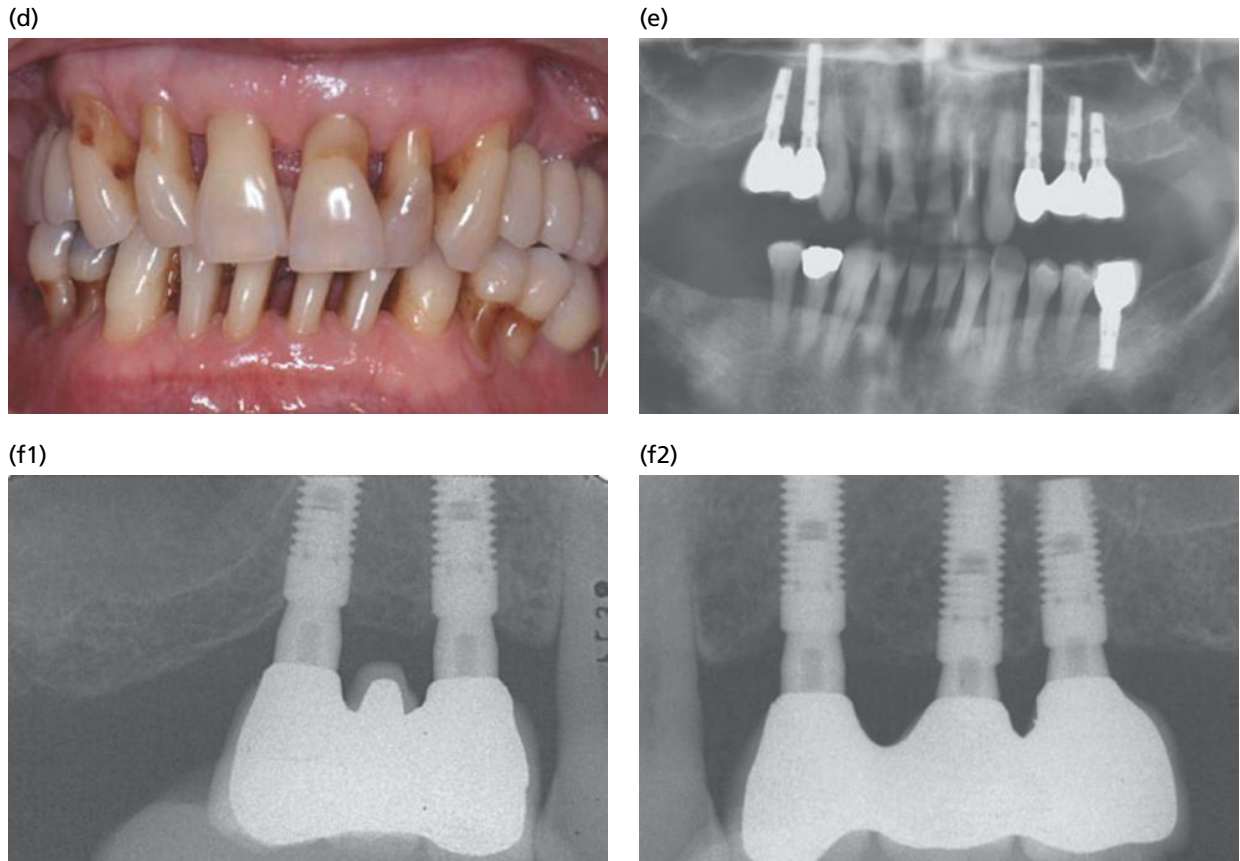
(Continued) (d–f) Clinical and radiographic status after completion of the implant treatment.
